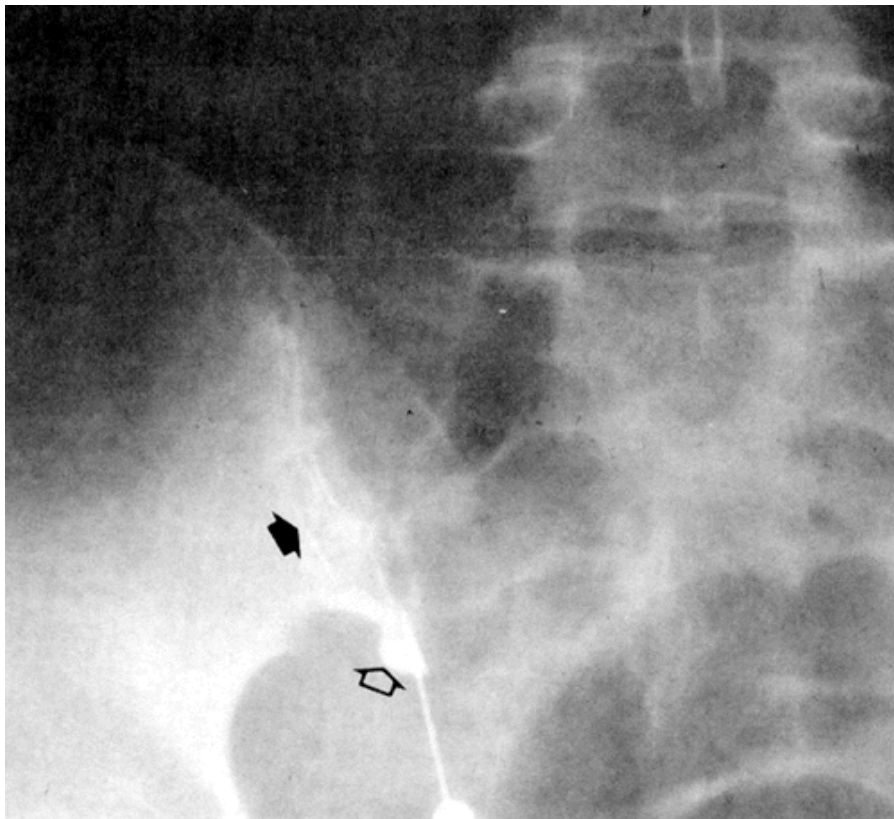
Radiographic representation of correct needle placement for sacroiliac joint block. The contrast material injected into joint space demonstrates an arthrographic pattern (black arrow) and filling of the inferior synovial capsule (white arrow).
